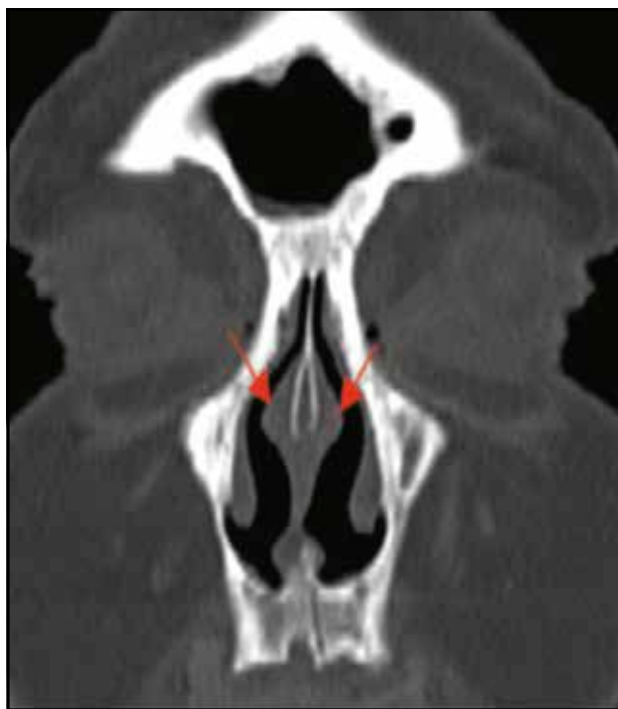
Cranio-facial CT scan, coronal section – bilateral aspect of the nasal swell body.
